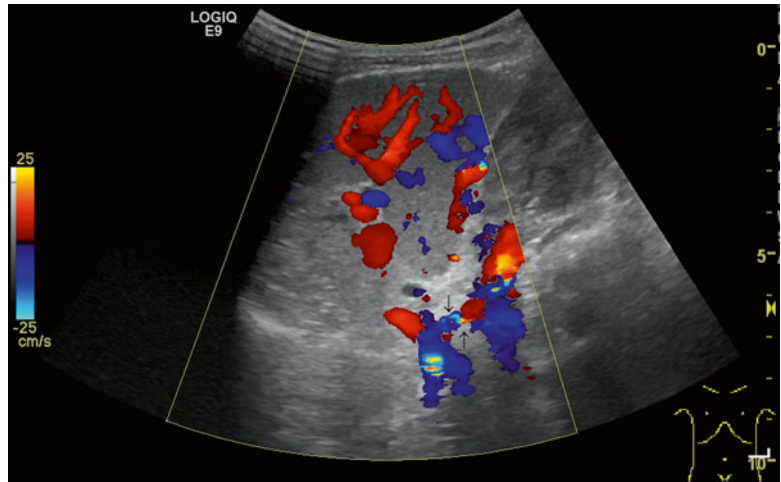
Portal hypertension in a 14-year-old patient with neonatal portal vein thrombosis. Multiple collaterals at the splenic hilus. (a) Multiple anechoic structures at the splenic hilus. Cross section through the spleen. (b) Colour Doppler reveals flow within the anechoic tubular structures and identifies them as portosystemic shunts (collaterals). Longitudinal section through the spleen. (c–e) Large spiral twisted splenic vein in an adolescent girl with neonatal portal vein thrombosis and excessive collateral network at the splenic hilus. (c) 2D image shows a spiral twisted dilated splenic vein. (d, e) colour Doppler of the flow in the dilated vein (d) and in varices at the splenic hilus (e)
